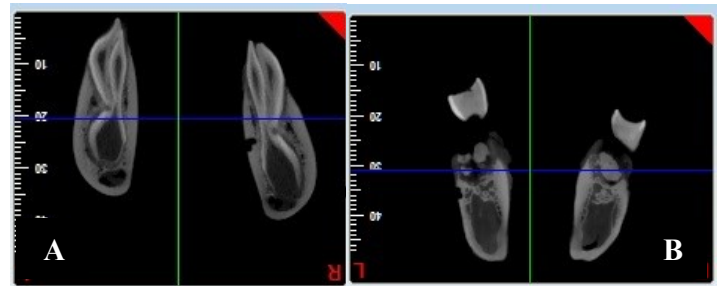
CBCT images of buccal (A) and lingual (B) bone defects
